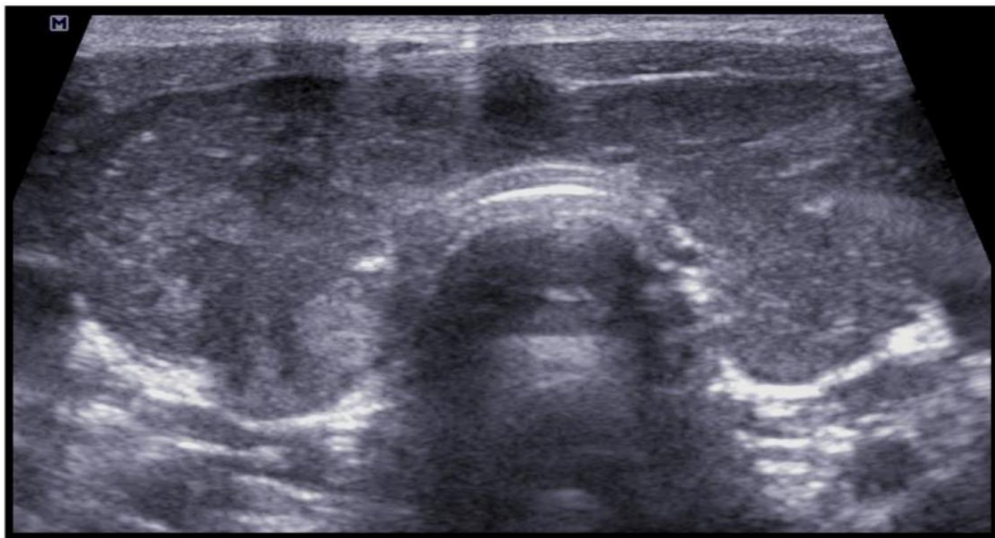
HRS USG showing in a patient of Grave's disease the diffusely enlarged, hypoechoic thyroid gland with diffusely increased vascularity on Color Doppler
